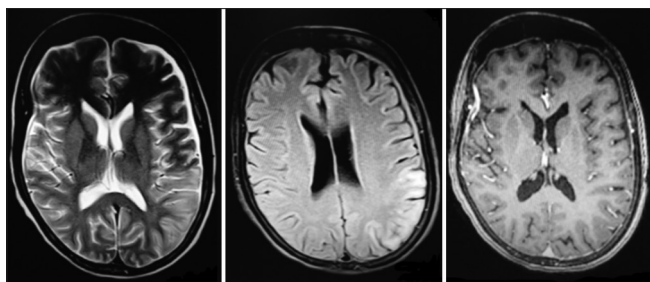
Left—cortical T2-weighted hyperintensity is seen in the left parieto-occipital region with mild hyperintensity seen in underlying subcortical white matter. Center—cortical FLAIR hyperintensity is seen in the left parieto-occipital region with mild hyperintensity seen in underlying subcortical white matter. Right—diffuse pachymeningeal contrast enhancement seen
